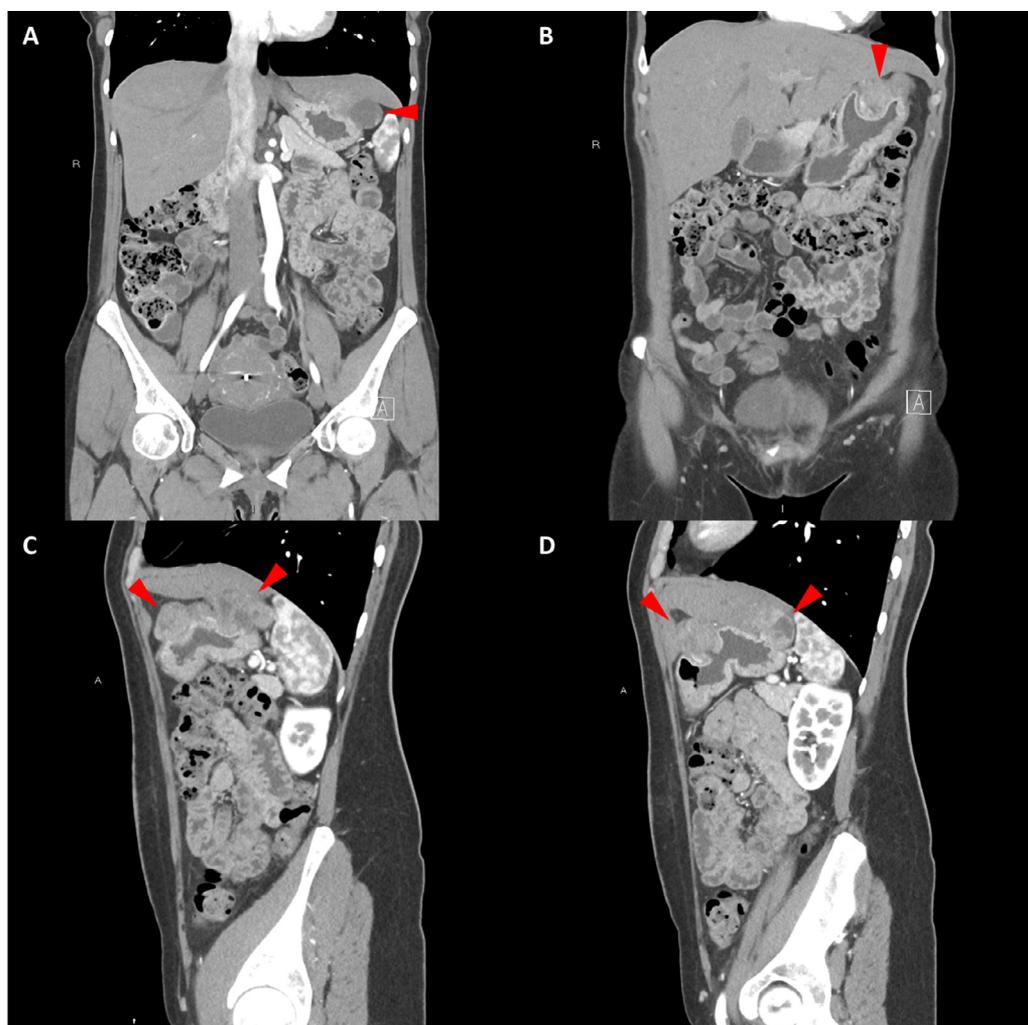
Coronal and sagittal images of multiple gastrointestinal stromal tumors. (A and B) Coronal arterial phase contrast-enhanced CT images show the exophytic masses arising from the gastric cardia. (C and D) Sagittal arterial phase contrast-enhanced images demonstrate the masses' heterogeneity and exophytic configuration.
